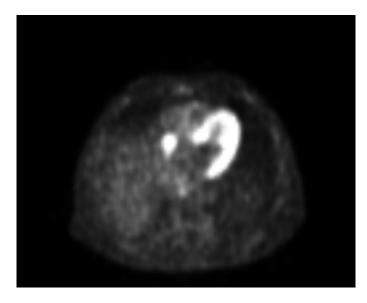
FDG uptake decreased in control PET-CT.
